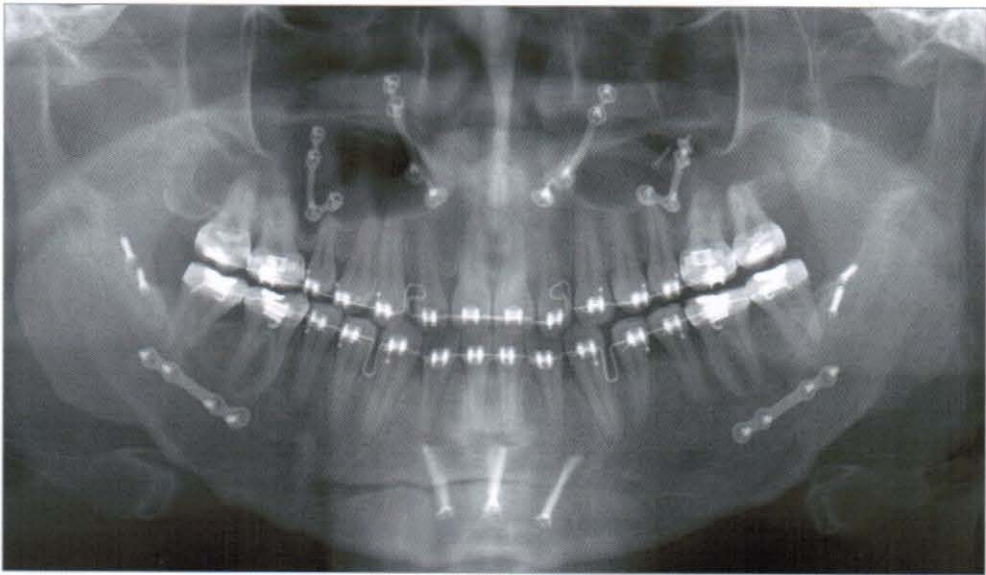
Postsurgical panoramic radiograph
